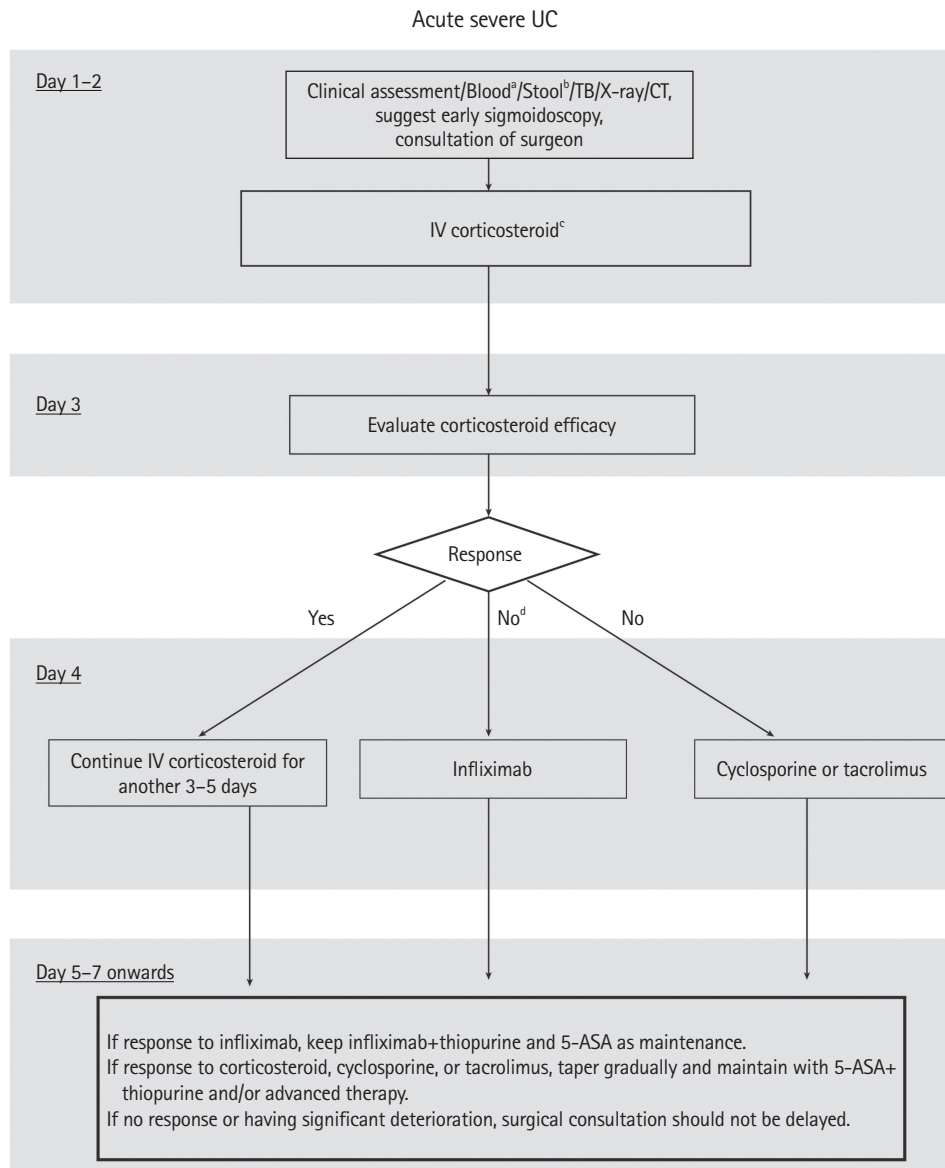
Recommended algorithm for the treatment of acute severe ulcerative colitis (UC). ^aComplete blood count, C-reactive protein, electrolytes, liver enzymes, hepatitis B virus, hepatitis C virus, etc; ^bStool culture, Clostridium difficile toxin, viruses; ^cMethylprednisolone 1 mg/kg/day or 60 mg/day, maximally, or hydrocortisone 100 mg × 4 times daily, maximally; ^dTreatment failure, C-reactive protein > 4.5 mg/dL & blood stool 3–8 times/day or bloody stool > 8 times/day. TB, tuberculosis; CT, computed tomography; IV, intravenous; 5-ASA, 5-aminosalicylic acid.
